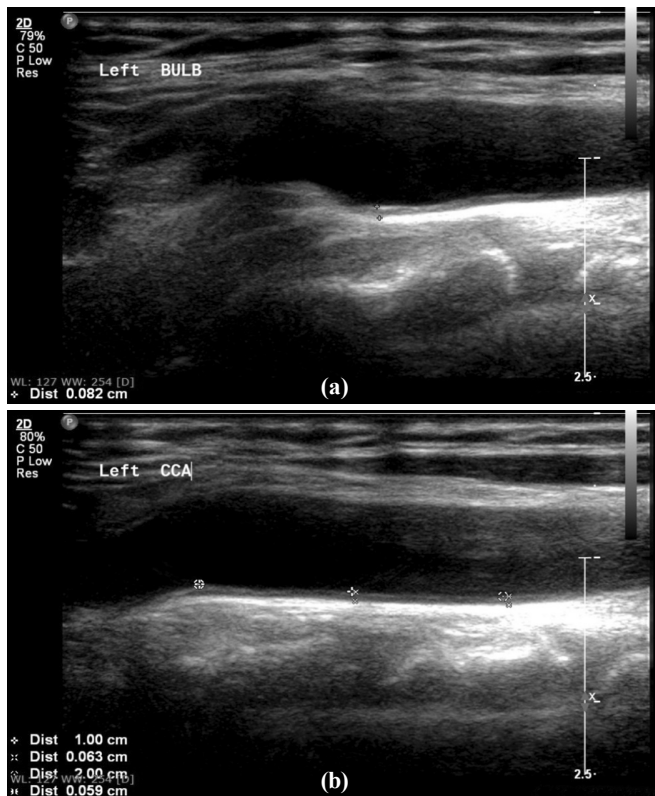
Longitudinal sonograms showing carotid intima-media thickness (CIMT) measured at (a) 0.5 cm and 1 cm, and (b) 2 cm from the bifurcation of the left common carotid artery
